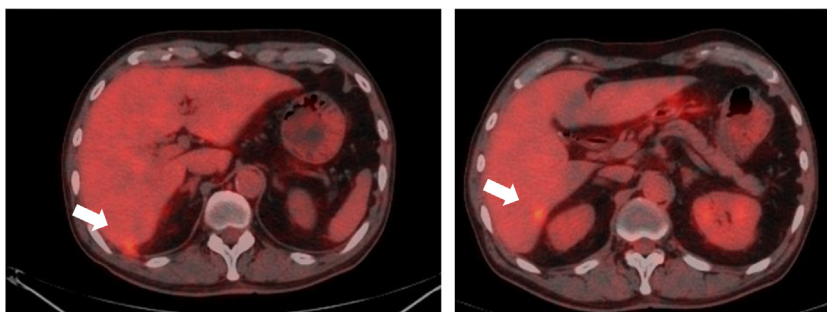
Preoperative PET-CT. Fluorodeoxyglucose positron emission tomography confirmed abnormal metabolic activity in the S6 lesion, with a high standardized uptake value of 4.27 (white arrow). PET-CT, fluorodeoxyglucose positron emission tomography.
